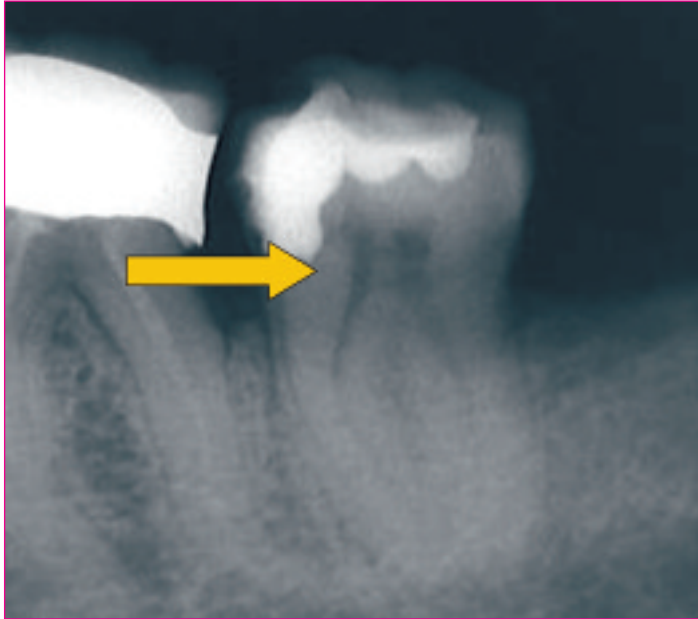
Pre-op radiographs showing a curvature and dentinal interference in the coronal third of the mesial root.
